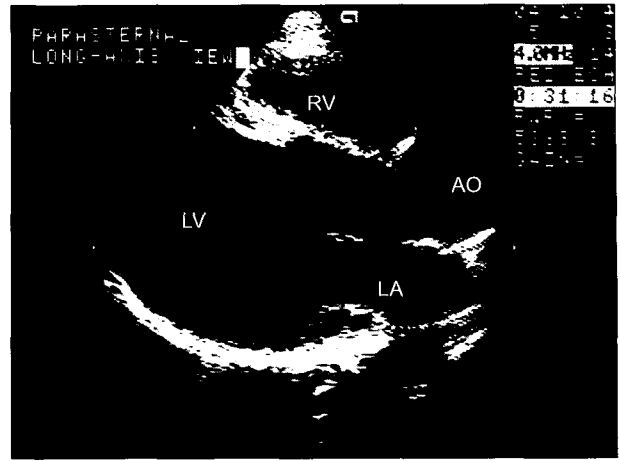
Postoperative echocardiogram 5 year after the operation: There were no signs of remnant tumor growth or left ventricular outflow tract stenosis.
